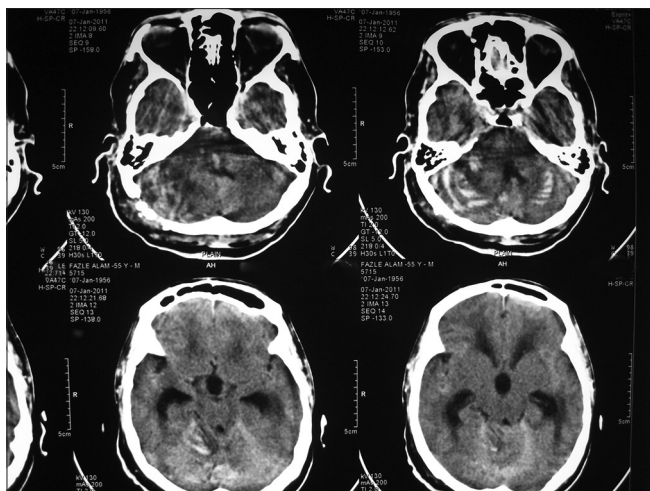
Postoperative computed tomography scan showing near total removal of tumor with little amount of hemorrhage
